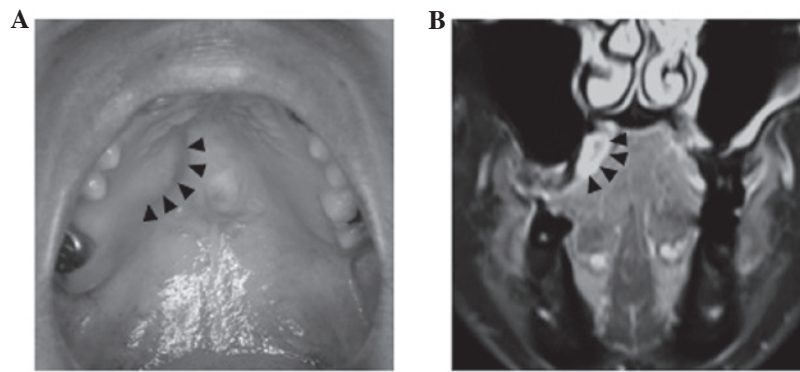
Intraoral findings at the first visit and magnetic resonance imaging view. (A) The mass was located on the right side of the hard palate. The surface showed normal mucosa (arrowheads). (B) Magnetic resonance imaging showed a high-intensity cystic mass with internal fluid on T1-weighted imaging of the right palatal region (arrowheads).
